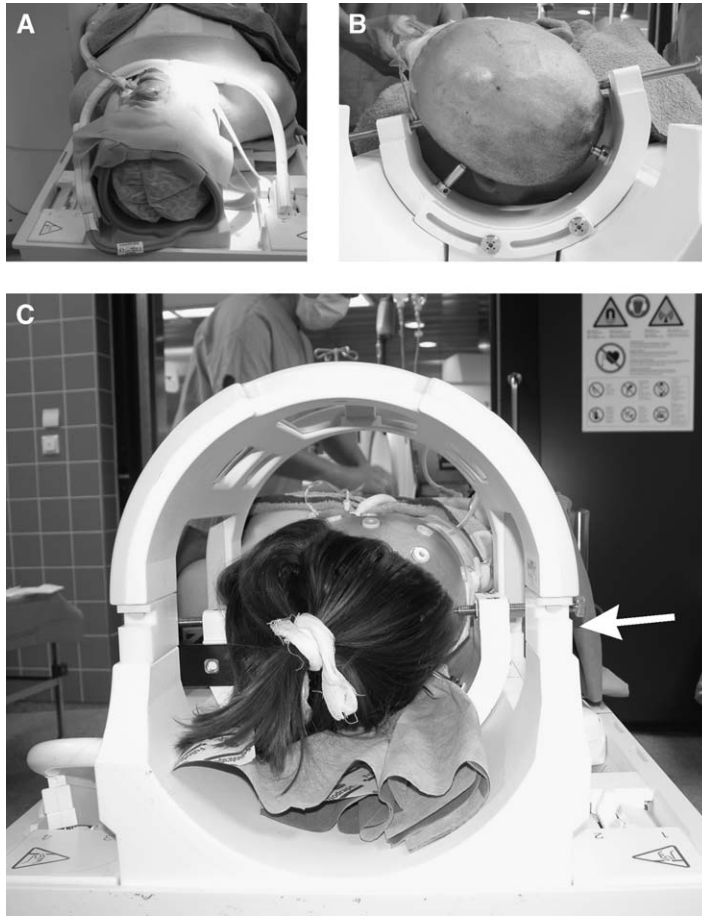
Different possibilities of coil placement. (A) In transsphenoidal surgery, a flexible coil is attached to the head and surgical access is not impeded. (B) In craniotomy procedures, the head is fixed in an MRI-compatible head holder, which is placed in the lower part of the standard head coil. (C) Sterile adapters (*white arrow*) are placed on the lower part of the head coil, allowing sterile placement of the upper part of the head coil during surgery (image depicts situation before surgery to show the details without draping).
